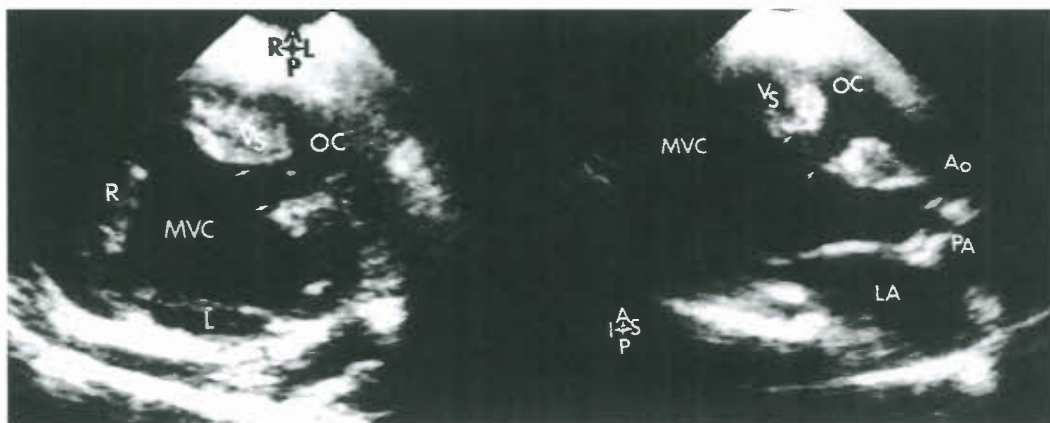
Parasternal short-axis (left panel) and long-axis (right panel) scans in a patient with DILV with previously placed pulmonary artery (PA) band. The VSD (arrows) is a moderately restrictive communication between the main ventricular chamber (MVC) and the outlet chamber (OC) of right ventricular morphology. In addition, the ventricular septum (VS) is moderately hypertrophied. Ao, aorta; L, left atrioventricular valve; LA, left atrium; R, right atrioventricular valve; RA, right atrium; VS, ventricular septum. (From Seward JB, Tajik AJ, Hagler DJ, et al. Two-dimensional echocardiographic Atlas. *Congenital Heart Disease*. Vol. 1. New York: Springer-Verlag, 1987:240, with permission.)
